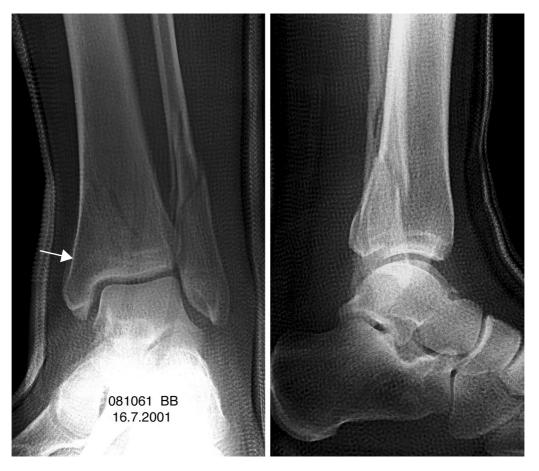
Anteroposterior and lateral radiographs of the same patient's ankle after closed reduction. The double contour (arrow) medially above the medial malleolus is visible but discrete. Note that the medial malleolus looks intact.
